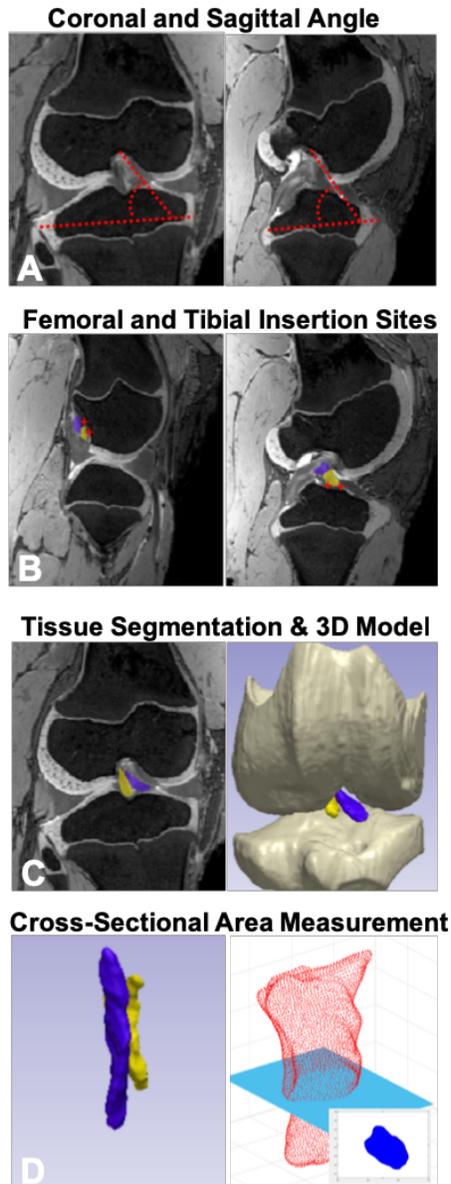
(A) Coronal and sagittal angles of the ACL bundles were measured on the most anterior (coronal, image shown) or the most medial (sagittal, image shown) slice depicting the full ACL relative to the anterior-posterior or medial-lateral plane of the tibial plateau (determined from a different MRI slice and transferred for measurement). (B) Bundle length was calculated between insertions (marked with red stars for the posterolateral bundle) based on points collected near the femoral and tibial insertion sites as shown in sagittal planes. (C) MR images were translated into three-dimensional models by creating masks for the individual tissues throughout the MRI scan and compiling the image masks to create 3D models. (D) The cross-sectional area was measured by isolating and rotating three-dimensional models of the ACL bundles, generating point clouds for each tissue, creating 2D cross-sections of these point clouds (shown in blue inset), and measuring the cross-sectional area at slices in the midsubstance of the tissue.
